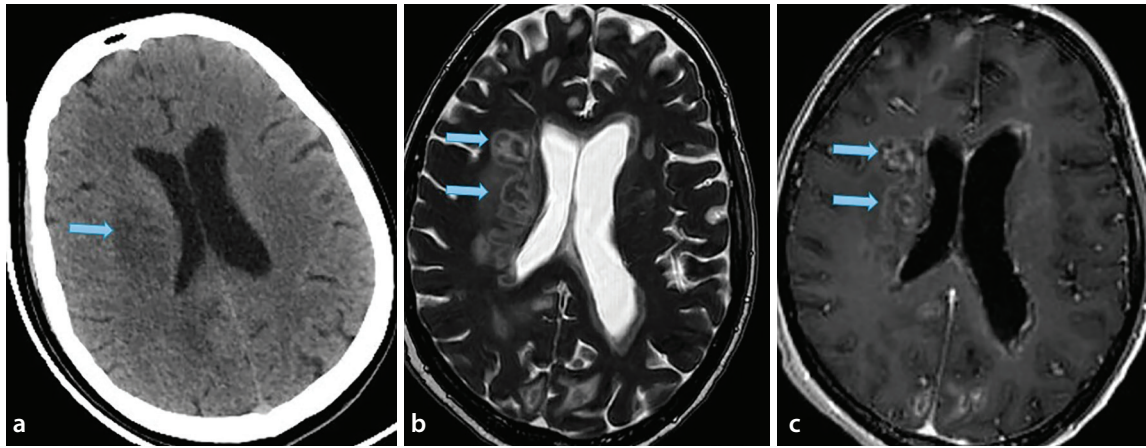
A 35-year-old woman who was HIV positive presented with severe headache and confusion. (a) Non-contrast brain computed tomography showed low-density lesions (arrows) in the right periventricular white matter. (b) Magnetic resonance imaging revealed peripheral hyperintense lesions with vasogenic edema (arrows) in T2-weighted images, with (c) peripheral contrast enhancement (arrows) on T1-weighted images, leading to a diagnosis of cerebral toxoplasmosis. HIV, human immunodeficiency virus.
